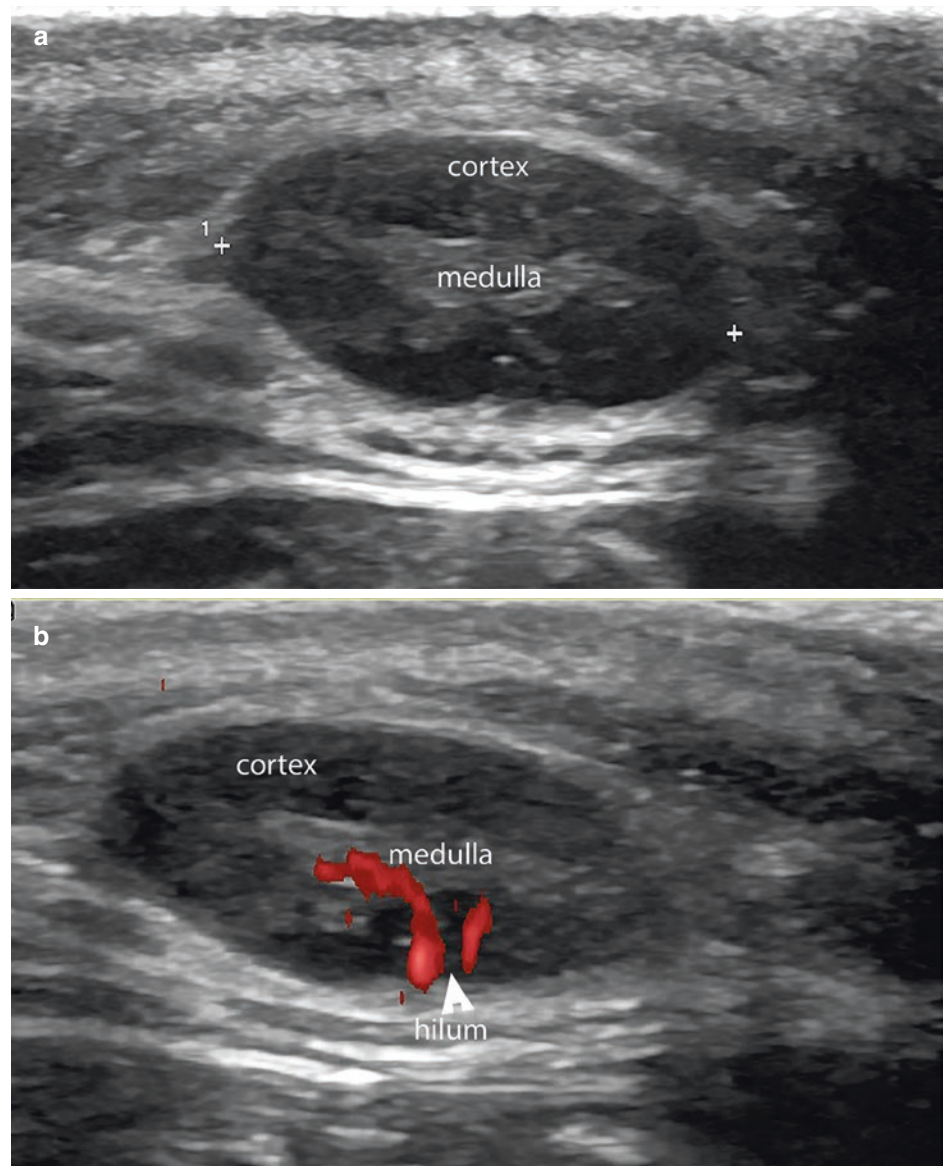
Ultrasonographic morphology of benign lymph nodes. (a) Greyscale. (b) Color Doppler shows well-defined, oval-shaped structures with an outer hypoechoic cortex and inner hyperechoic medulla. In (b) the vascular hilum is located in a border and the vascularity tends to be centripetal.
